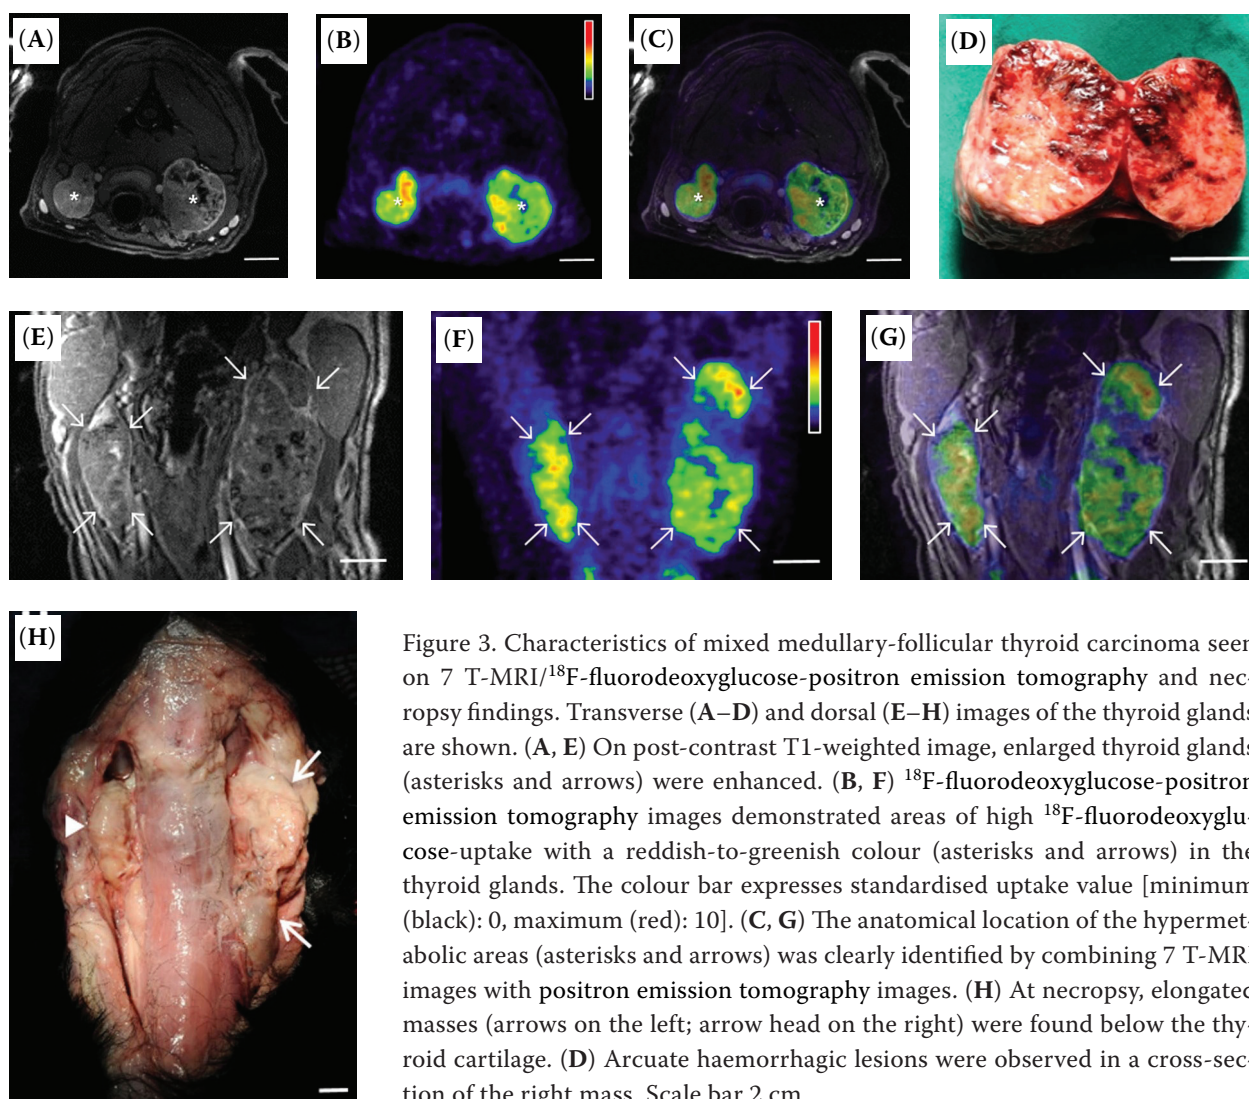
Characteristics of mixed medullary-follicular thyroid carcinoma seen on 7 T-MRI/ $^{18}\text{F}$ -fluorodeoxyglucose-positron emission tomography and necropsy findings. Transverse (A–D) and dorsal (E–H) images of the thyroid glands are shown. (A, E) On post-contrast T1-weighted image, enlarged thyroid glands (asterisks and arrows) were enhanced. (B, F)  $^{18}\text{F}$ -fluorodeoxyglucose-positron emission tomography images demonstrated areas of high  $^{18}\text{F}$ -fluorodeoxyglucose-uptake with a reddish-to-greenish colour (asterisks and arrows) in the thyroid glands. The colour bar expresses standardised uptake value [minimum (black): 0, maximum (red): 10]. (C, G) The anatomical location of the hypermetabolic areas (asterisks and arrows) was clearly identified by combining 7 T-MRI images with positron emission tomography images. (H) At necropsy, elongated masses (arrows on the left; arrow head on the right) were found below the thyroid cartilage. (D) Arcuate haemorrhagic lesions were observed in a cross-section of the right mass. Scale bar 2 cm
